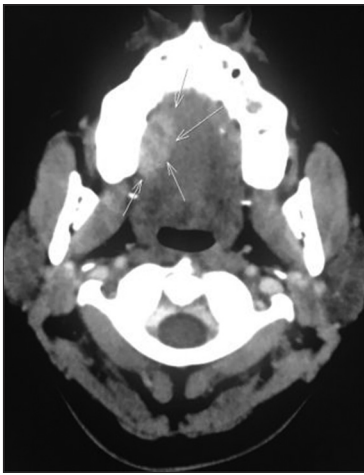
Axial computed tomography revealing a soft-tissue density in the right lateral aspect of the hard palate
